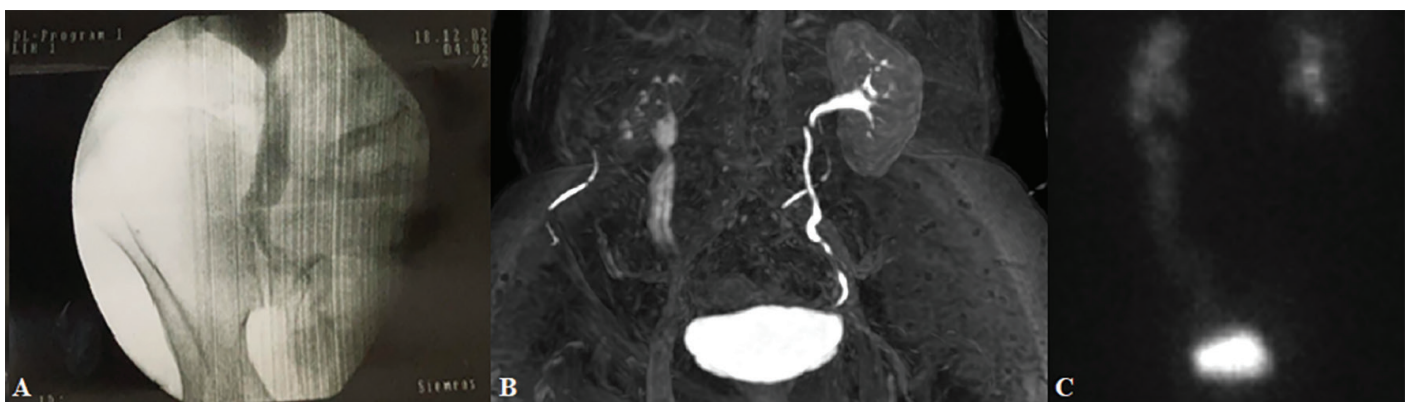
Images from the postoperative follow-up of the patients. A. Antegrade pyelography image of Case 2, in the first postoperative month. B. MR-urography image of Case 2, six months after the surgery. C. Dynamic renal scintigraphy image of Case 3, six months after the surgery
